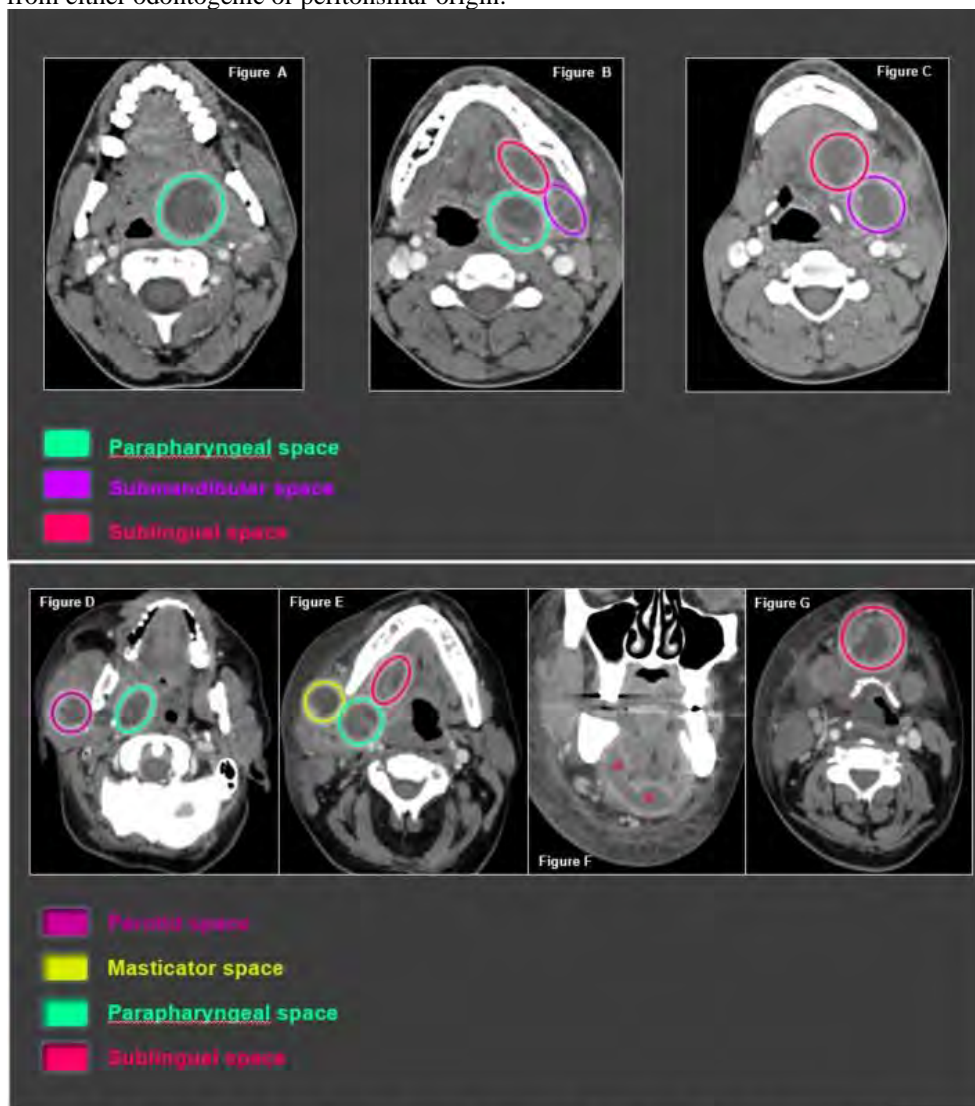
a-c) CT scan of a 28 year old male with history of sore throat and left neck pain with multicompartmental abscess extending from the left tonsillar pillar into the floor of mouth and involving the left submandibular and sublingual spaces. d-f) CT scan of a 41 year old female with history of recent right tooth extraction presenting with multicompartmental abscess involving the right parotid, masticator, submandibular, and sublingual spaces, likely of odontogenic origin.
